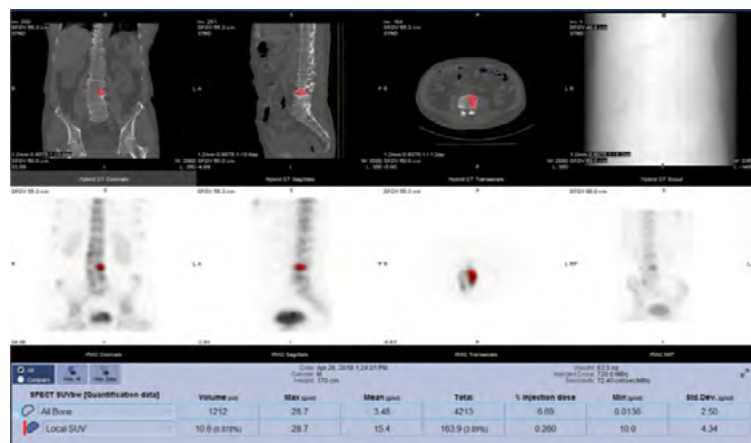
Bone SPECT quantification showing the uptake in a lumbar spine bone lesion in terms of SUV_{max} , SUV_{mean} , SUV_{min} together with the volume of the lesion. Also shown in the figure for reference is the SUV of the total segmented bone in the image data.
